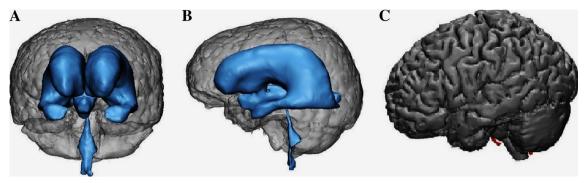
Digital 3D surface of the ventricular system (a, b) and brain (c) generated from the preoperative rendered MRI studies of a 14-year-old patient with hydrocephalus
